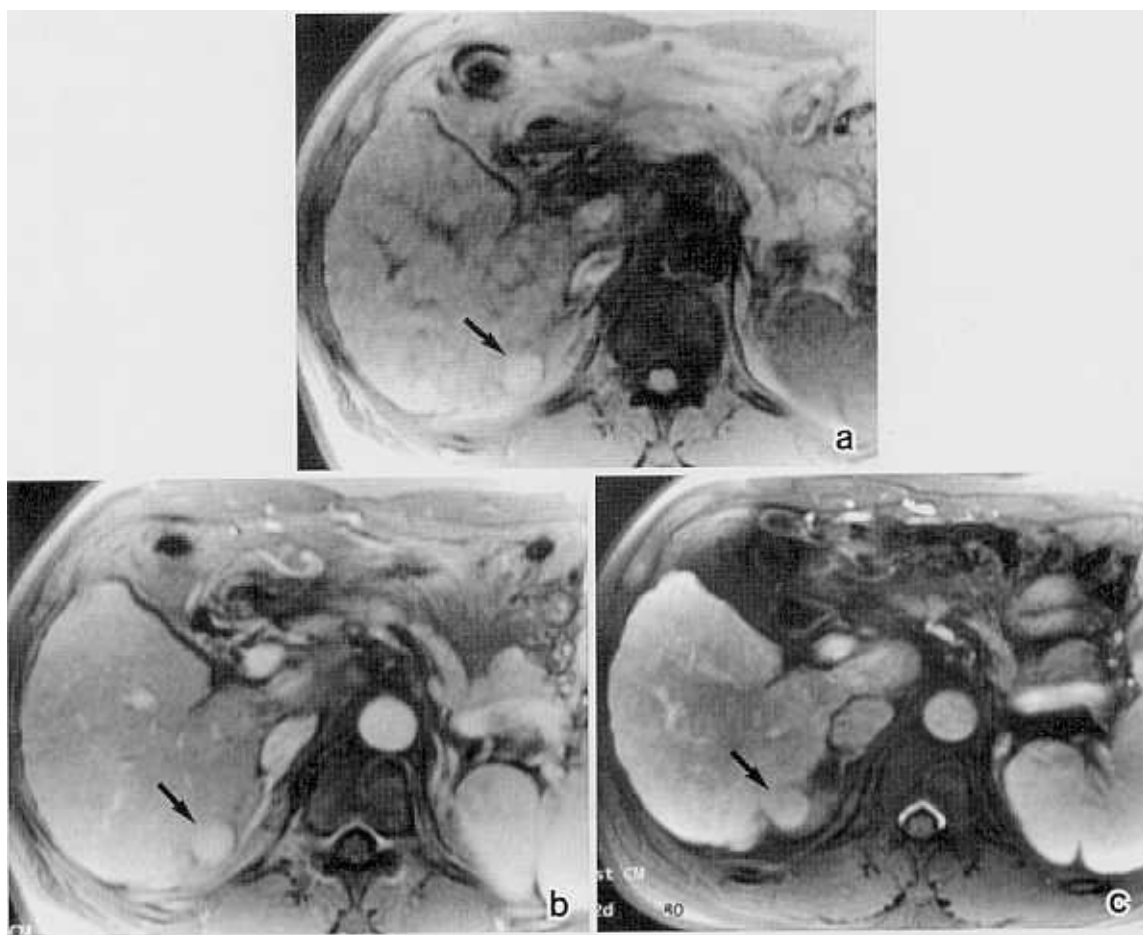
Benign hepatocellular nodule mimicking hypervascular hepatocellular carcinoma on dynamic MR imaging in a 47-year-old man with liver cirrhosis. (a) Unenhanced T1-weighted MR image shows a high signal intensity nodule (arrow) in right lobe of liver. (b) Contrast-enhanced MR image obtained during first phase (arterial dominant phase), 10 sec after intravenous administration of contrast agent was started, shows a high signal intensity nodule suggesting contrast enhancement of hypervascular tumor. (c) MR arterial portogram obtained during second phase of imaging 55 sec after initiation of contrast material injection via superior mesenteric artery shows no distinguishable perfusion defect. There was no iodized oil uptake and no evidence of tumor growth in the corresponding location on follow-up imaging studies (not shown) for a 14-month period.
